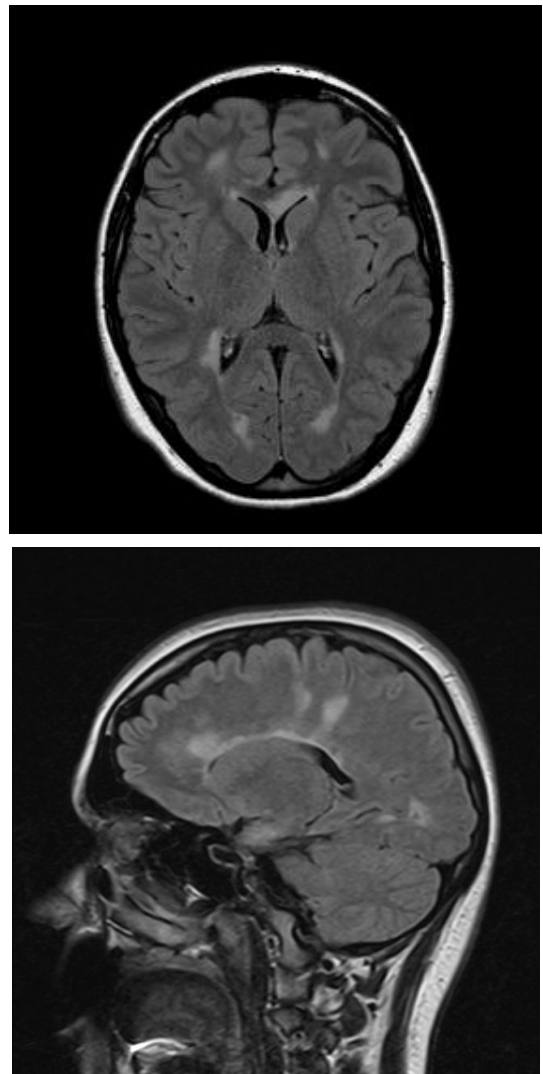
Axial and sagittal T2 FLAIR images showing periventricular, corpus callosal, and juxtacortical white matter lesions.
